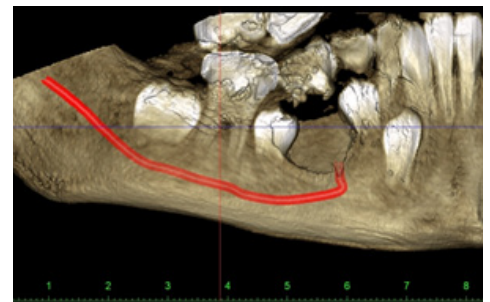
CBCT depicting the mental foramen which is seen inferior to the cystic lesion
